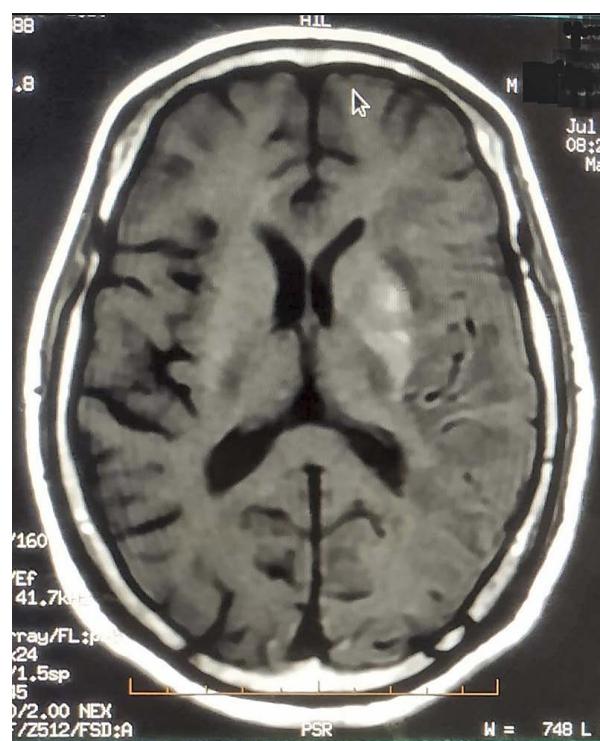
An axial T1-weighted MRI image demonstrates hyperintense lesions involving bilateral putamina (left more than right), characteristic of diabetic striatopathy.
